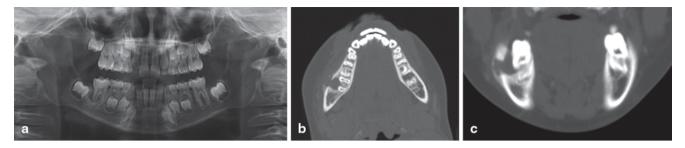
a Panoramic radiograph demonstrating U-shaped radiolucency around the root of the lower, right first molar. Axial (b) and coronal (c) CT cuts show cortical perforation with a well-circumscribed lesion located on the buccal surface of the involved tooth
